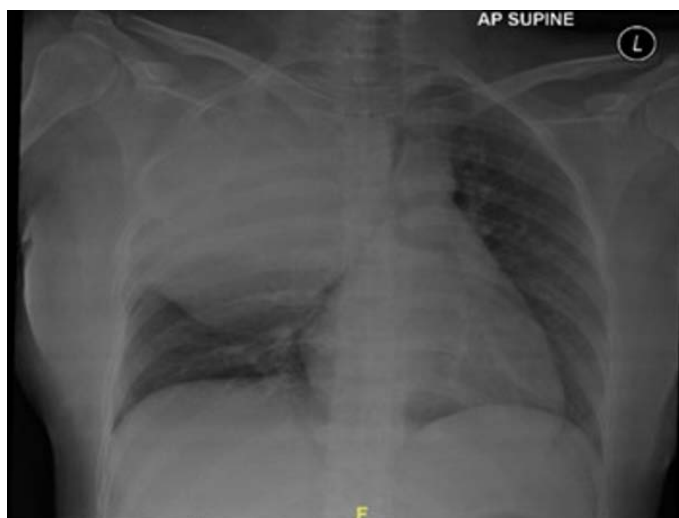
Chest radiograph showing incidental findings of a large right apical lung mass with left tracheal deviation
